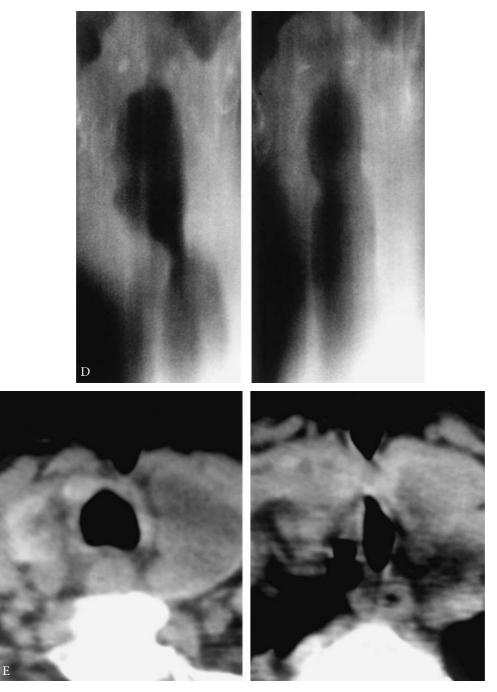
(CONTINUED) D, Tomograms outlining areas of stomal stenosis and anastomosis pre- and postoperatively (left and right images, respectively). Note the irregularity of the right side of the subglottic larynx preoperatively. There is slight narrowing at the anastomosis. E, Computed tomography scans comparing a nearly normal trachea at left image with side-to-side narrowing of a stomal stenosis on the right image. Indentation of the cutaneous scar is seen. At bronchoscopy and operation, the anterior cricoid cartilage proved to be completely eroded, and thus required laryngotracheal resection and reconstruction. Imaging and endoscopy are both essential before an operation.
